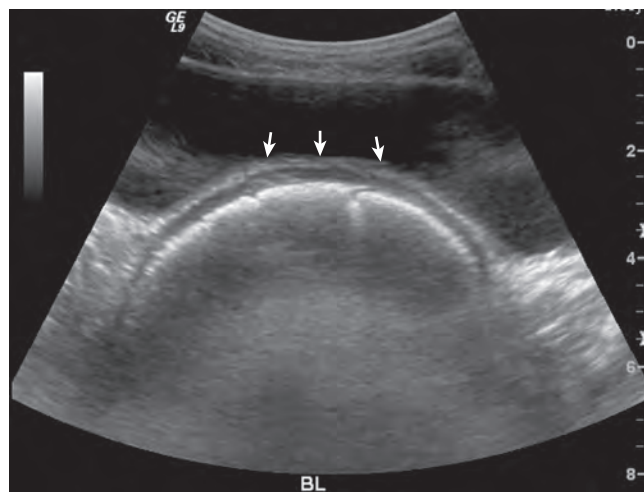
Pelvic ultrasound demonstrates anterior displacement of the bladder wall with decrease in functional bladder capacity as a result of a large amount of fecal material in the rectum (arrows).
